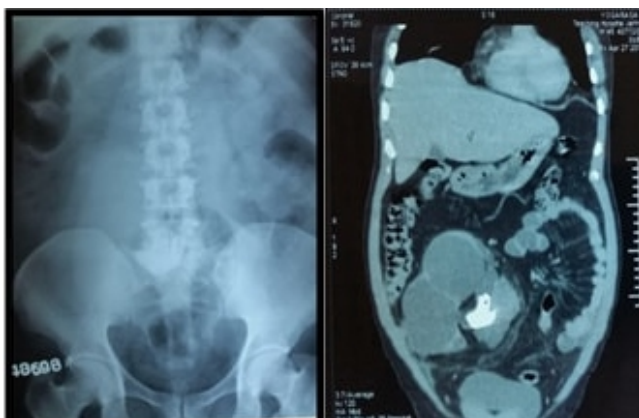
X ray KUB and CT KUB revealing large staghorn Calculus at the level of L5 vertebra level and crossed ectopia of left kidney with hydronephrosis and calculus respectively
